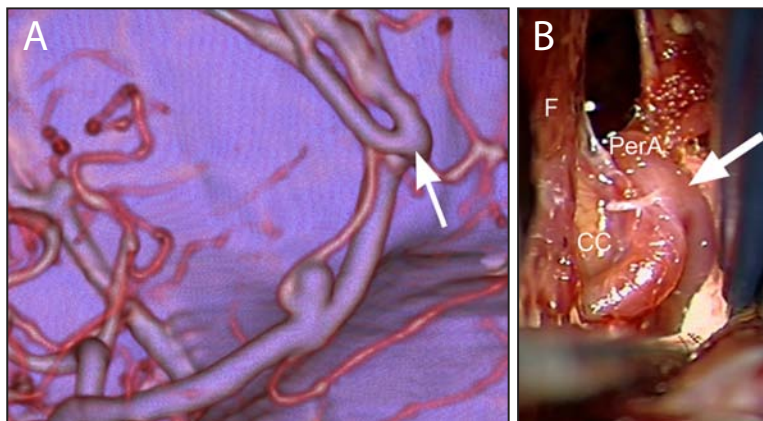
(A) Azygos ACA with A2 trunk aneurysm as seen on CTA. (B) Intraoperative picture of the same patient during anterior interhemispheric approach showing the azygos ACA (PerA) with the bifurcation (arrow), the falx (F) and the corpus callosum (CC) (see DACA — video 4).
